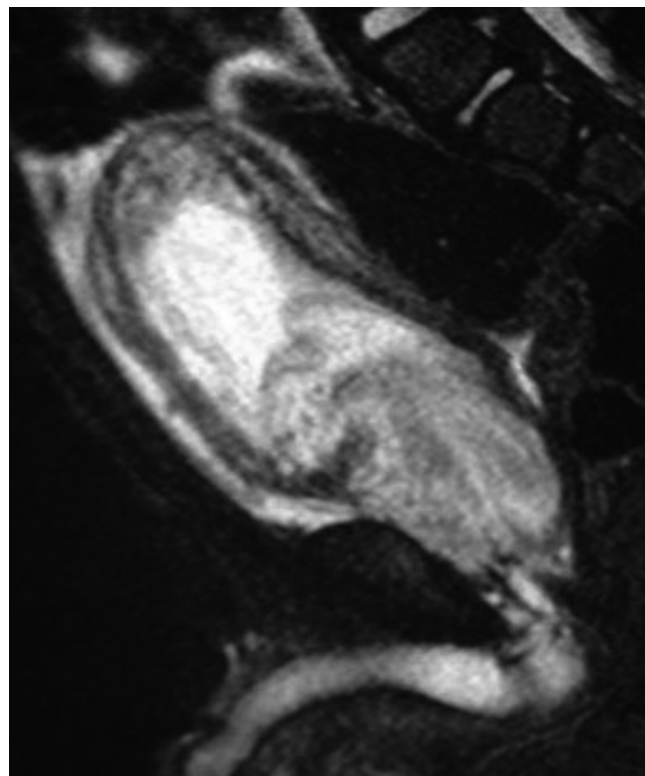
Bladder neck and urethra RMS in a 2 year-old boy (Sagittal T2 weighted MRI)
